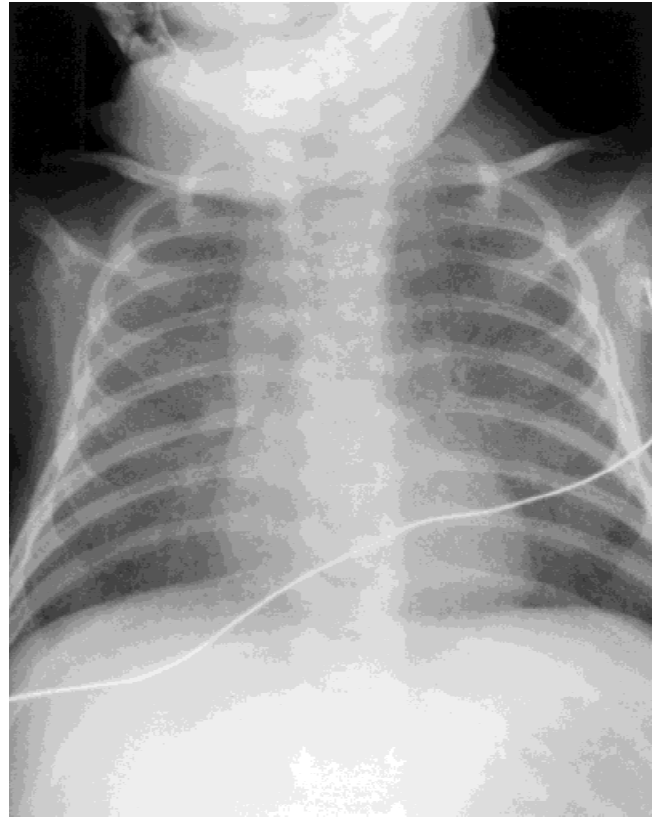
PA chest X-ray of the infant at initial presentation, demonstrating diffuse alveolar infiltration.
